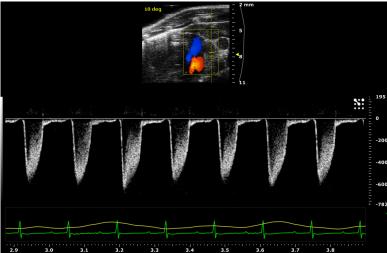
Pulmonary Artery velocity display in PW Doppler Mode
